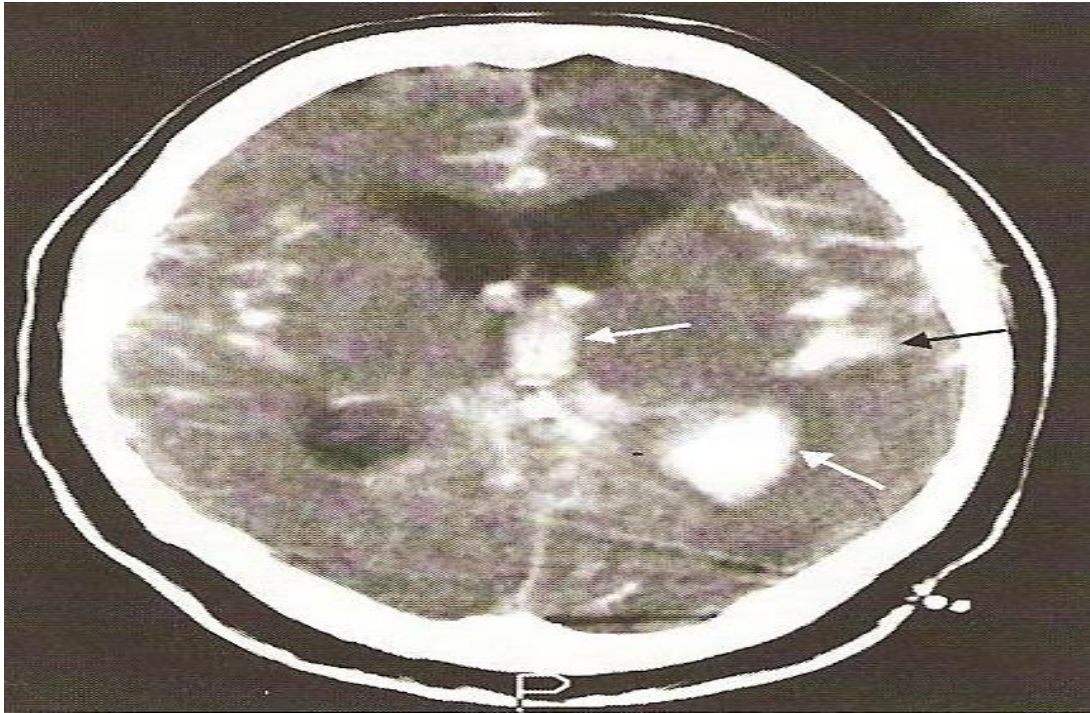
Subarachnoid Hemorrhage(Interpretation of Emergency Head CT Erskine J. et.al 2008).
